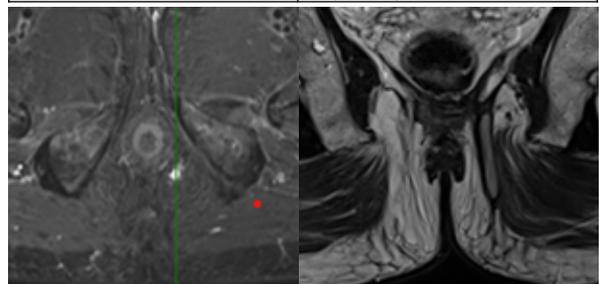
MRI STIR and T2 Images Show High Trans Sphincteric Fistula.
